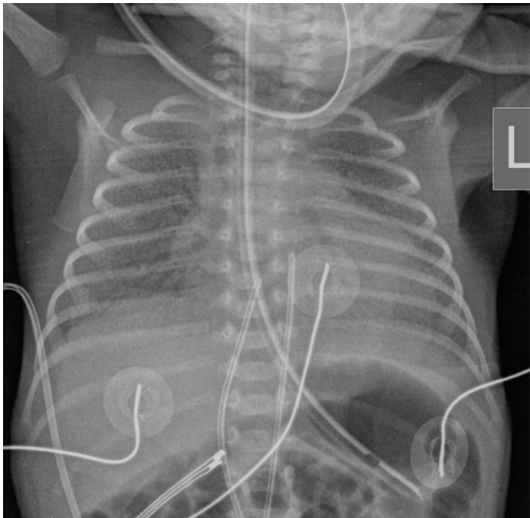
Newborn girl born premature at 28 weeks gestation with surfactant deficiency disorder. Frontal chest radiograph demonstrates diffuse bilateral hazy pulmonary opacities and low lung volumes.
